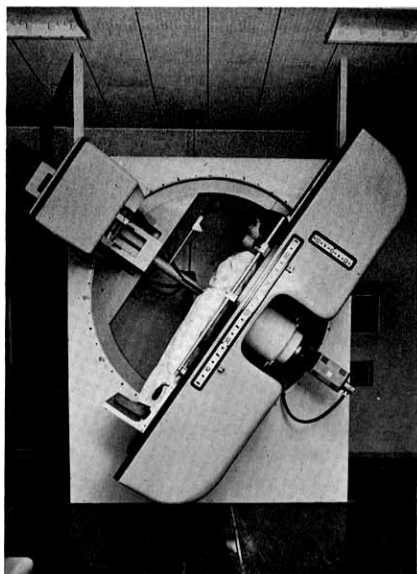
The diagnostic table which is used with the x-ray television unit for roentgen diagnosis is operated completely by remote control.
